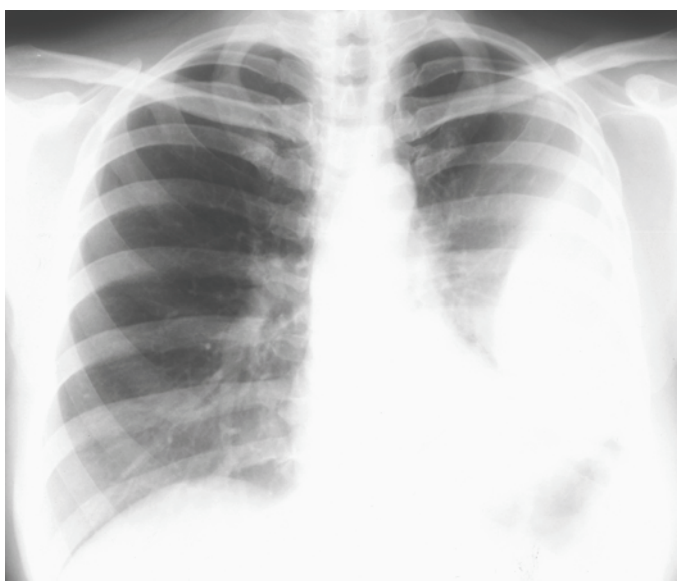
Chest radiograph. Left pleural effusion.
